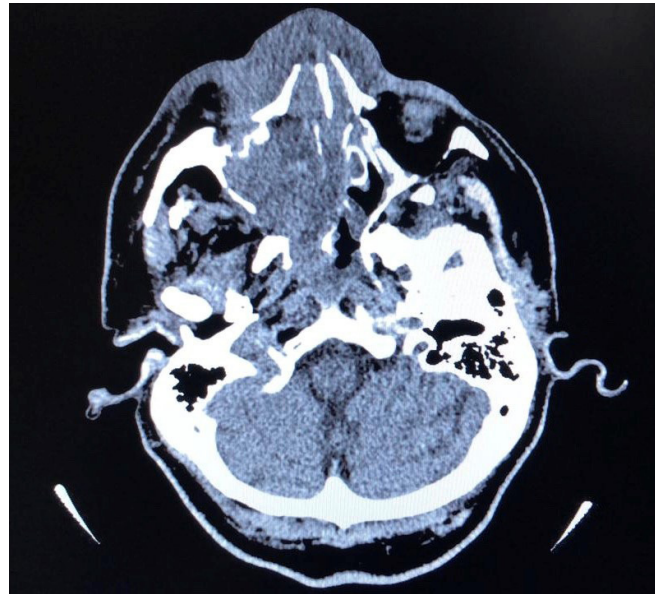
CT scan, axial image, showing a mass with destruction of nose septum and right nasal sinus.
